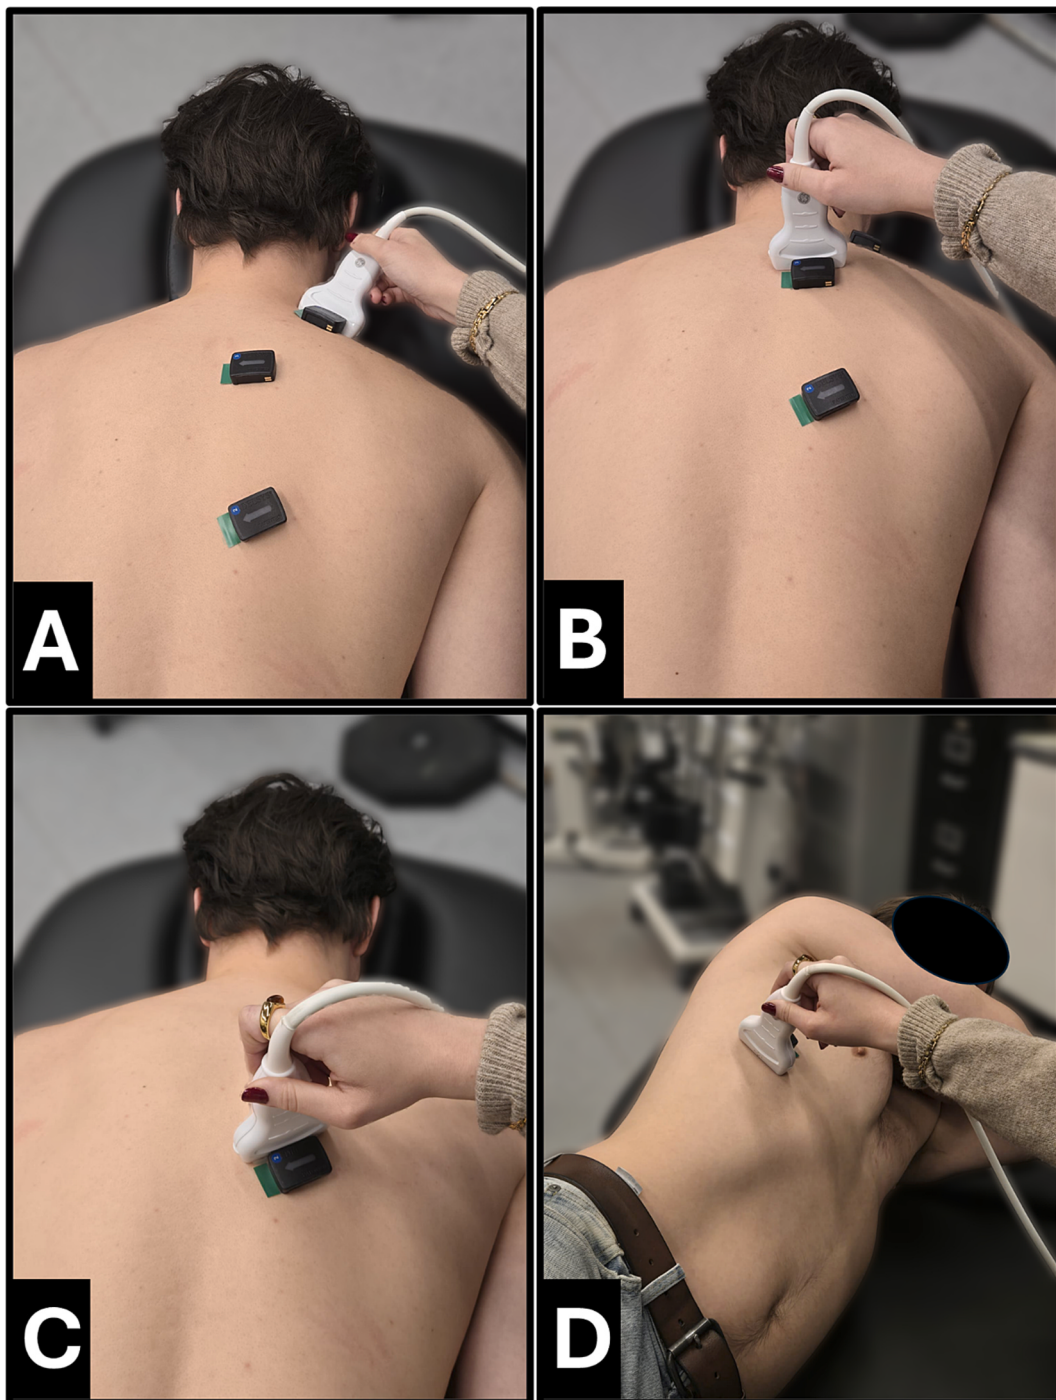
Resting ultrasonographic shear wave velocity testing postures for A. upper trapezius B. middle trapezius C. lower trapezius and D. serratus anterior.
